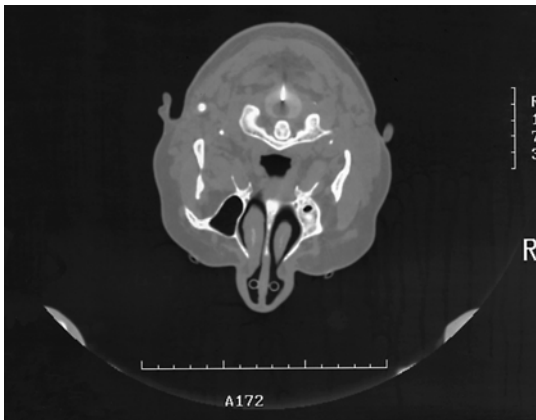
Final position of the cannula on axial CT scan at occiput-C1 level in extralemniscal myelotomy
